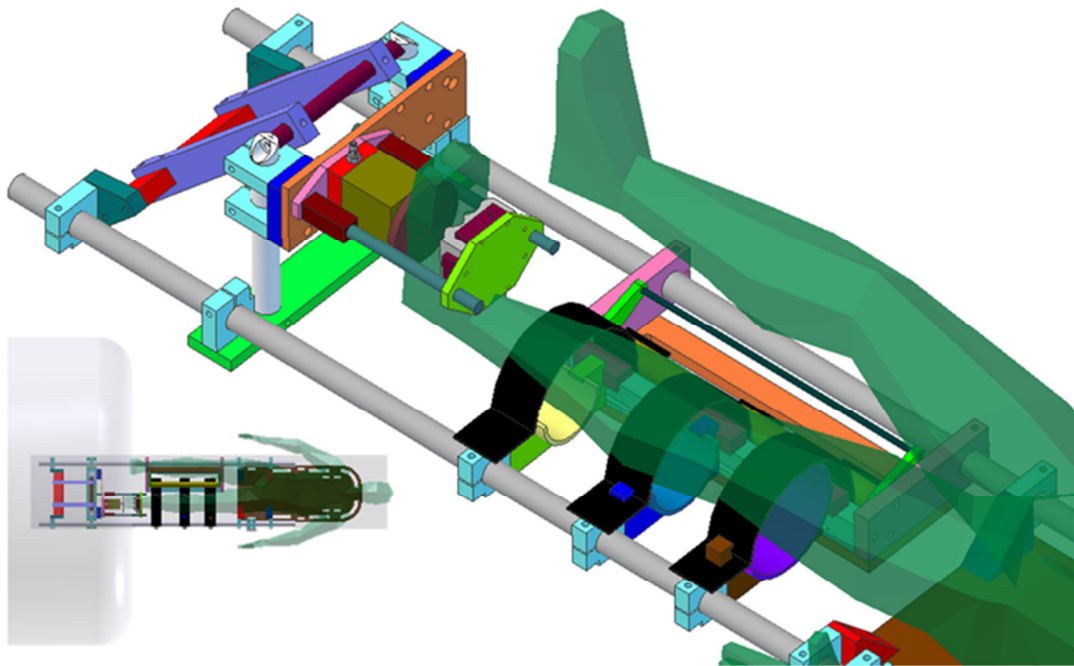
CAD assembly of human loading apparatus (inset shows assembly entering MRI bore)
